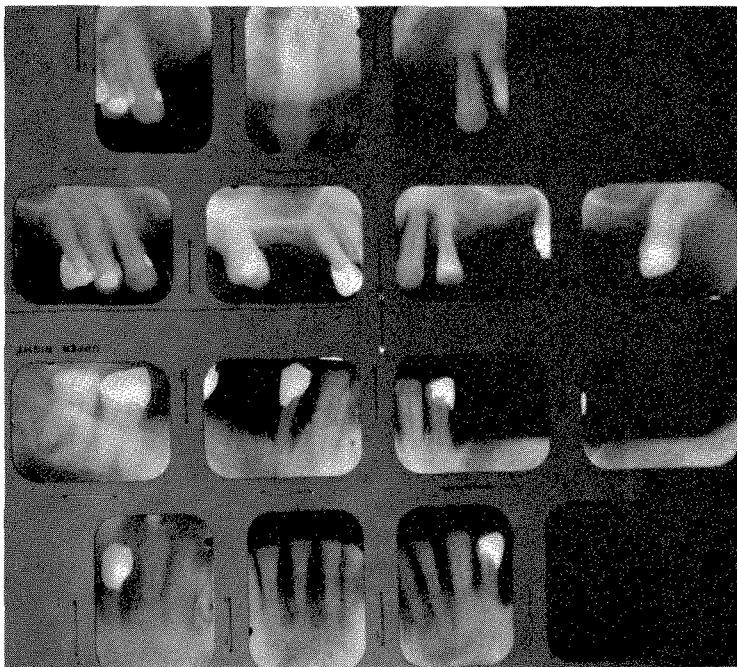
Roentgenograms taken in October, 1945.
